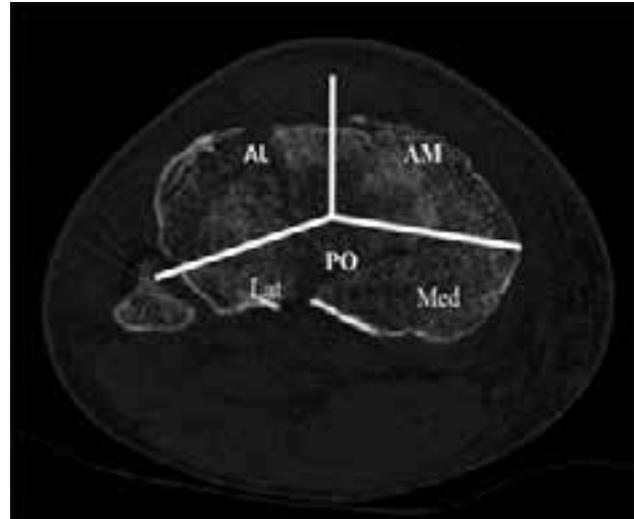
CT based 3 column classifications (AL- anterolateral, AM- anteromedial, PO- posterior)
